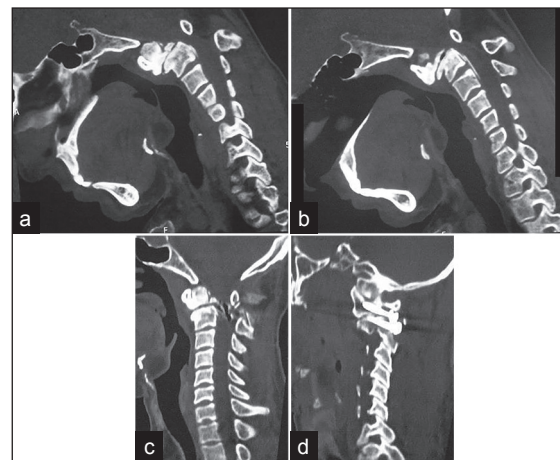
(a) Sagittal image of computed tomography scan of a 32-year-old male patient. He suffered road traffic accident 10 years prior to treatment. The symptoms of quadriparesis increased over the period of time. The image shows chronic odontoid fracture. (b) Lateral sagittal image showing ossified posterior longitudinal ligament at C2-C3 level. (c) Postoperative image showing distraction, reduction and fixation of the atlantoaxial joint. (d) Images showing the implant in the facets
